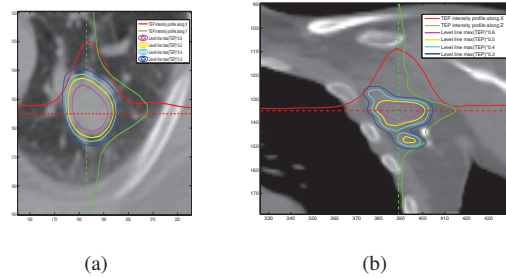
PET intensity profiles overlaid on CT data for: (a) a lung tumor and (b) a lymph node. Level lines of PET intensity are superimposed for values between $0.6 \times \max(\text{PET})$ in red and $0.3 \times \max(\text{PET})$ in blue.
